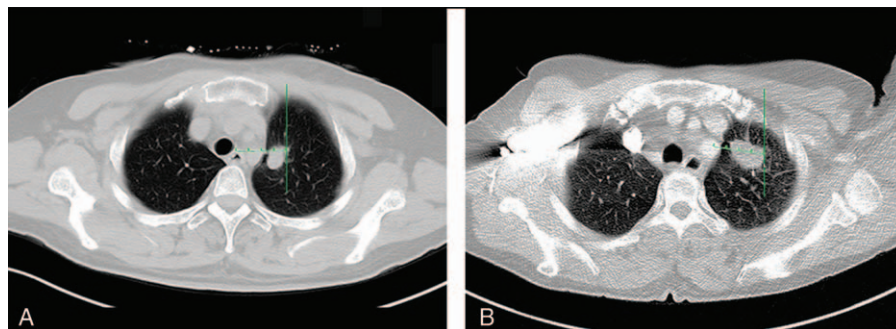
Definitions of paramediastinal lesion and nonparamediastinal lesion. A, CT image of a 49-year-old female showed a 16 mm nodule in left upper lobe. The distance from the exterior margin of the lesion to the nearest mediastinum was 18 mm (less than 3 cm). It was classified as a paramediastinal lesion. B, CT image of a 51-year-old female shows a 30 mm nodule in the left upper lobe. The distance from the exterior margin of the lesion to the nearest mediastinum is 35 mm (exceed 3 cm). This lesion was classified as a non-paramediastinal lesion. CT = computed tomography.
